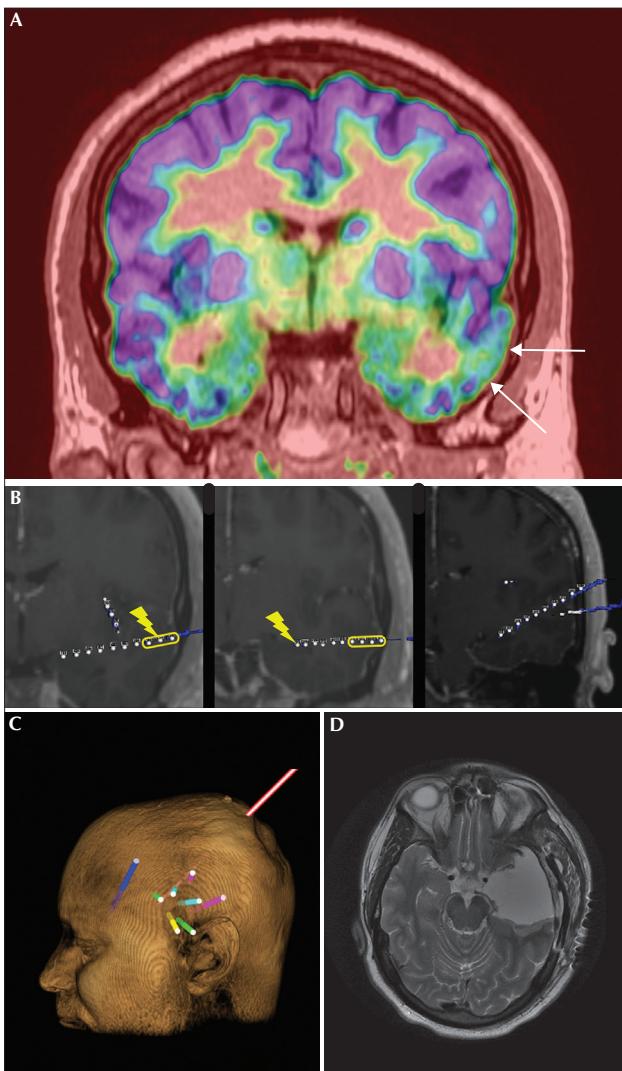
(A) Left temporal hypometabolism (arrows) in a patient with mirthful laughter seizures demonstrated by ^{18}F -fludeoxyglucose positron emission tomography. (B) The left, middle, and right panel show the depth electrode contacts at the level of the amygdala, as well as the anterior and posterior hippocampus, respectively. The neocortical seizure onset zones are highlighted with yellow boxes. Stimulation of one contact in the anterior superior temporal gyrus neocortex electrode (left panel; lightening symbol) triggered a typical laughing seizure at 2 mA. Stimulation of the anterior hippocampus electrode contact (middle panel; lightening symbol) with 2 mA triggered epigastric rising, nausea, and induced speech arrest, and made the patient feel as if he was going to have a laughter seizure. (C) Stereoelectroencephalography implantation scheme covering the left temporal (lower row: yellow/green/pink electrodes) and orbitofrontal lobe (dark blue electrode), the opercular region (upper row: light green/light blue/pink electrodes), as well as the insula (light blue and oblique red electrode). (D) T2-weighted magnetic resonance imaging after left anterior temporal lobectomy.
